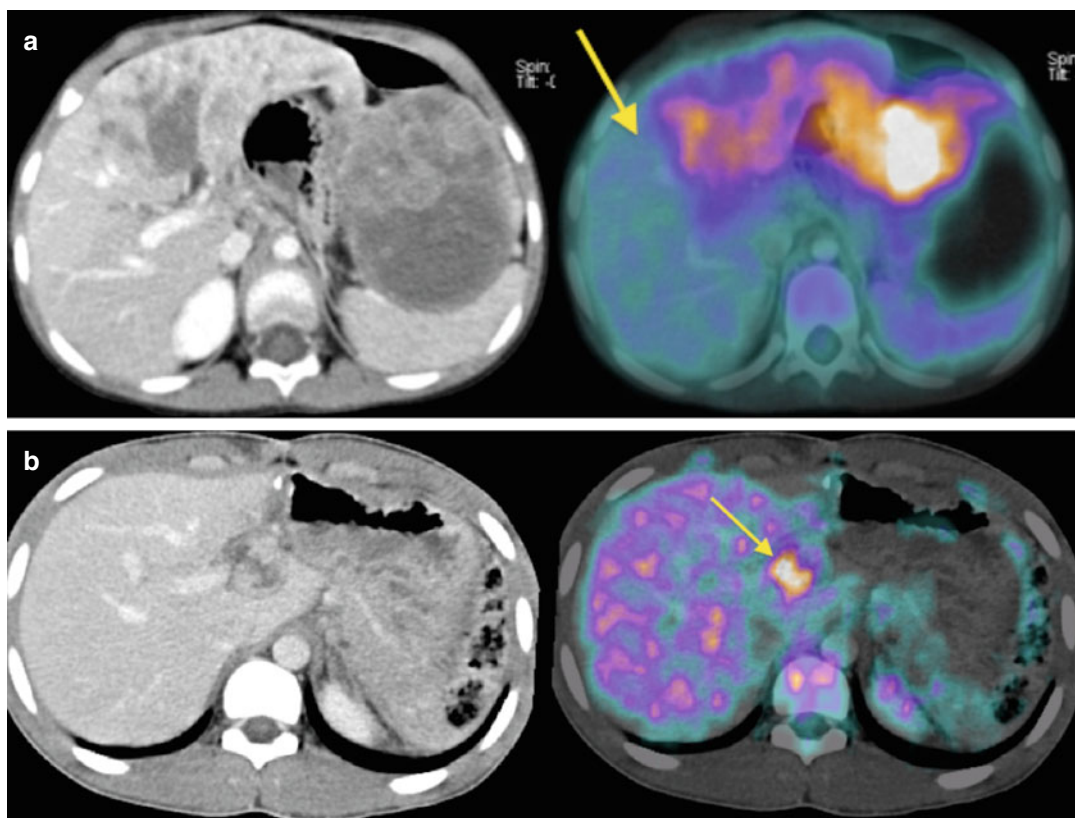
(a) Primary hepatoblastoma in a 5-year-old female with axial CT (*left*) and ^{18}F -FDG PET/CT scan (*right* co-registered image) showing moderate increase in ^{18}F -FDG uptake (SUVmax 5.3) in viable tumor. There is no ^{18}F -FDG uptake in the left side of the mass, which is undergoing necrosis. The PET was considered helpful by the surgeon in defining the resection margin (*arrow*). (b) Recurrent hepatocellular hepatocarcinoma in a 9-year-old male who had resection of the primary tumor 12 months
